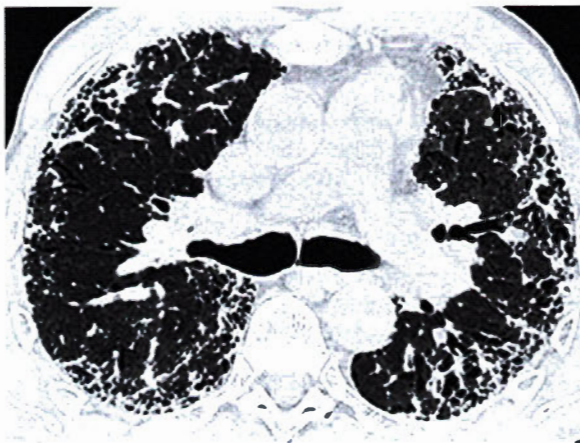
Chest CT: pulmonary fibrosis
